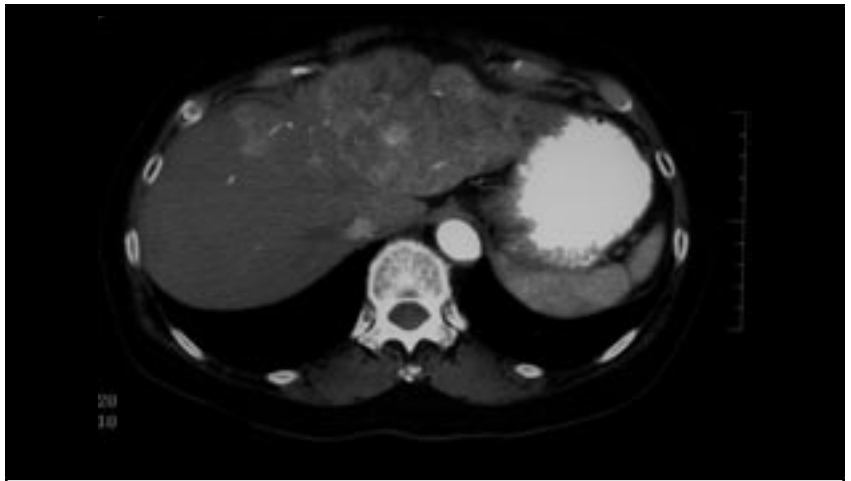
Large heterogeneous enhancing mass in left lobe. (CT taken on Nov. 29, 2002)
